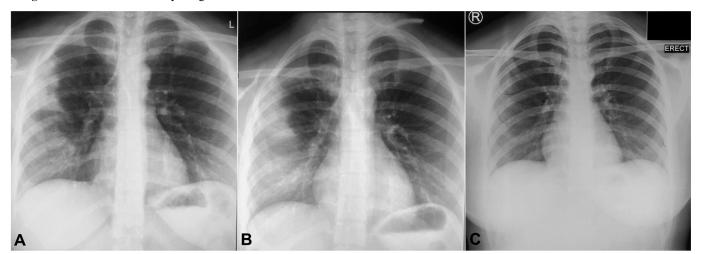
Patient's Chest X-Ray Images.
